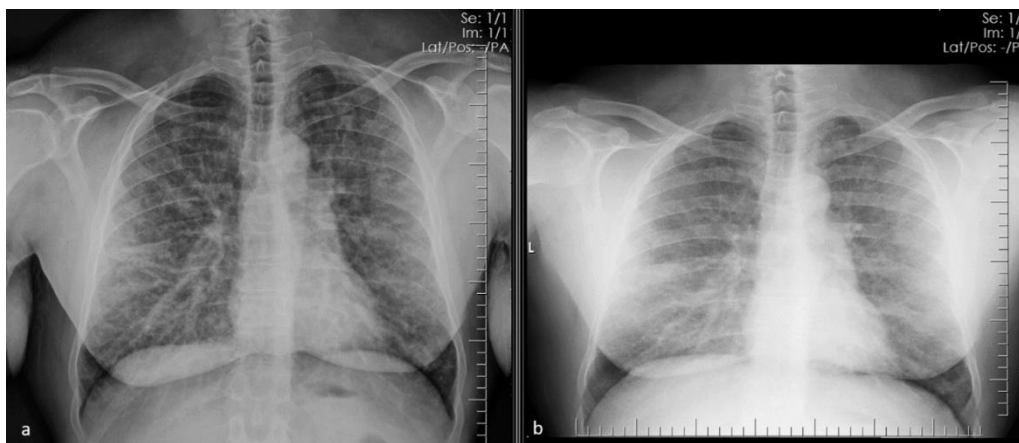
At the end of the first week of treatment with corticosteroids findings on chest x-ray were recorded. Chest X-ray before the treatment (a), and chest X-ray after the first week of treatment (b).
